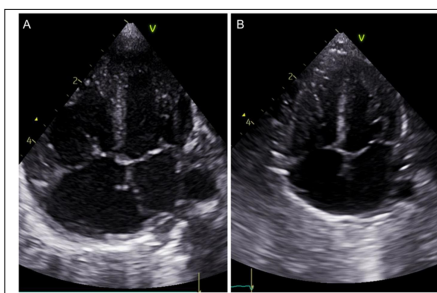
Echocardiographic apical four-chamber views before and after embolisation.
